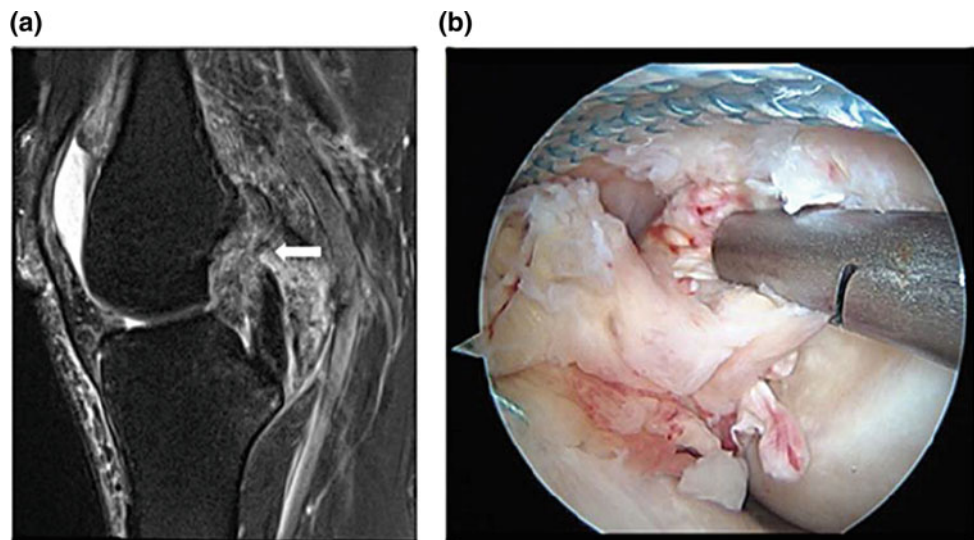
a Sagittal T2-weighted fat-suppressed MRI demonstrates a full-thickness tear of the PCL (*arrow*). Based on the proximal location of this tear, eligibility for primary repair is deemed likely. b Arthroscopic assessment of the PCL tear (in the right knee) of the same patient. The ligament has adequate length and tissue quality to perform primary repair
